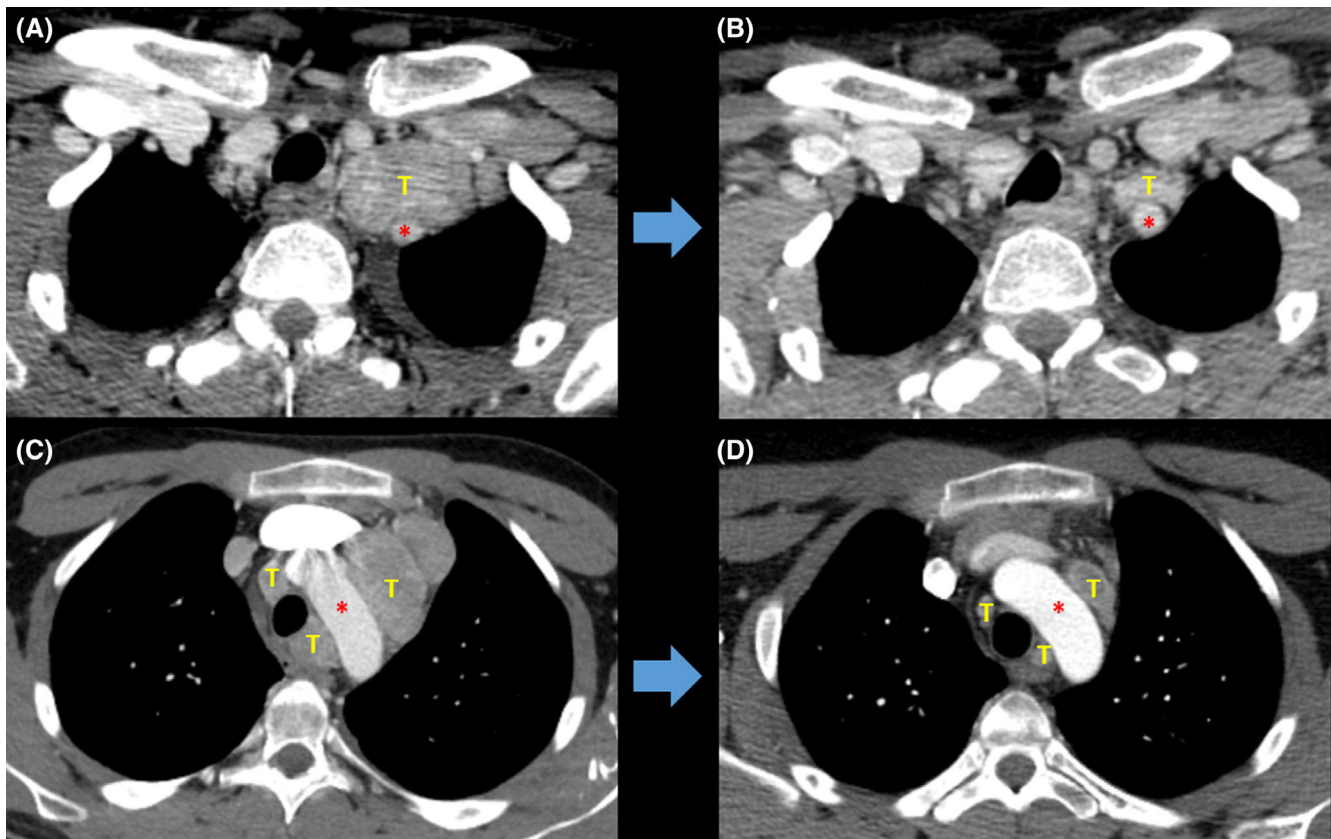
CT findings prior to and following neoadjuvant selpercatinib. Panels A and C depict the extent of neck and superior mediastinal lymph node prior to neoadjuvant treatment. Panels B and D depict the extent of neck and superior mediastinal disease following 3.6 months of neoadjuvant treatment. In panel A, the tumor (yellow letter T) is wrapped $>180^\circ$ around the subclavian artery (asterisk), while in panel B, the tumor has regressed considerably, with a better defined interface with the subclavian artery. In panel C, there is significant tumor (yellow letter T) wrapped around the aortic arch (red asterisk), such that both the left phrenic and recurrent laryngeal nerve would be at considerable risk with surgery, while in panel D, the tumor has regressed considerably, putting these nerves at much lower surgical risk. Overall response by RECIST 1.1 after 3.6 months of Selpercatinib was 51.5%
